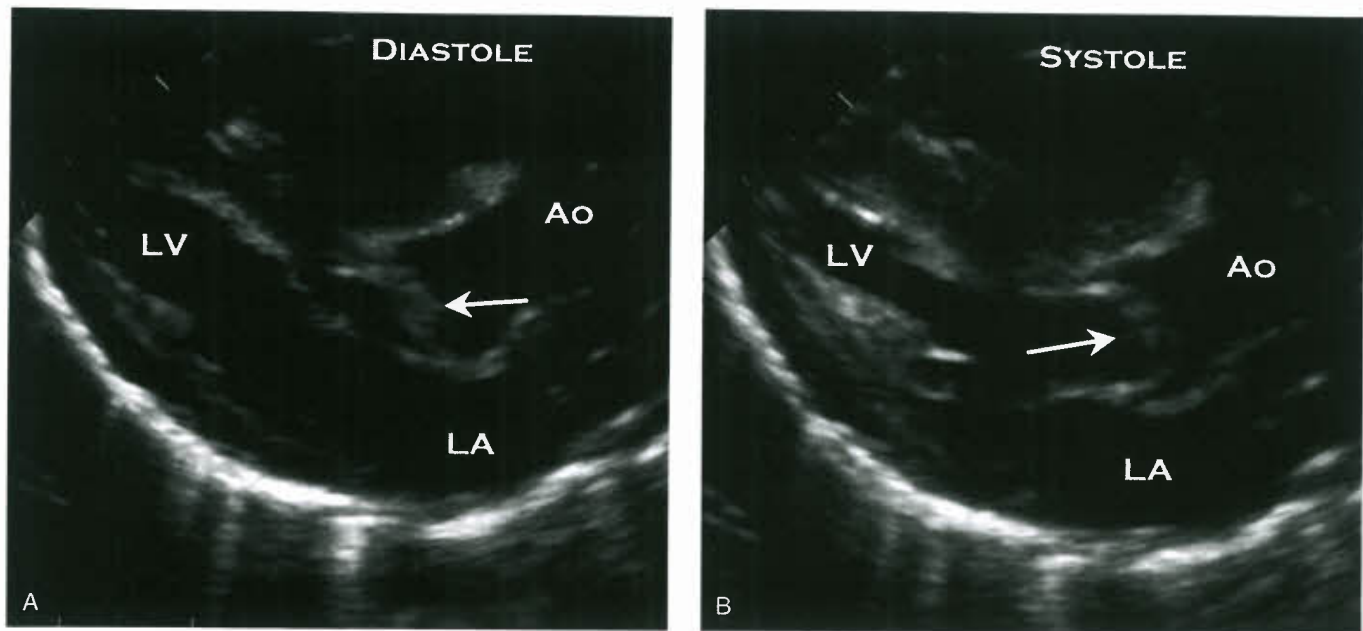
Echocardiographic parasternal long-axis views of a stenotic aortic valve. A: Diastole. B: Systole. LV, left ventricle; LA, left atrium; Ao, aorta; arrow, thickened valve leaflets that dome during systole.
